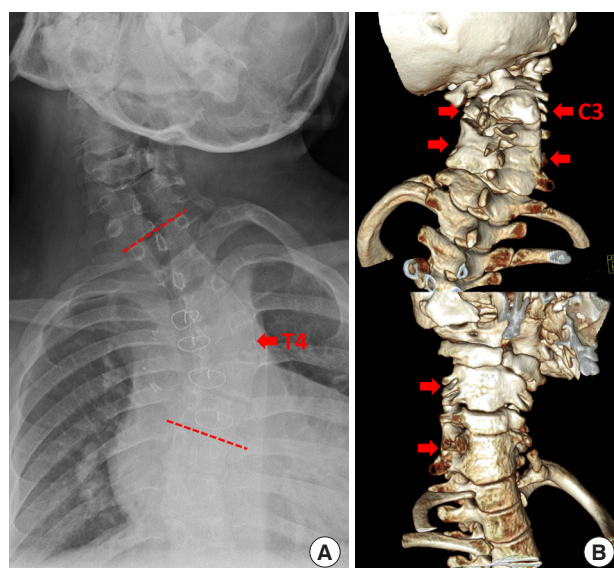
(A) Plain radiography reveals left thoracic scoliosis at T4 with 50 degrees of Cobb's angle. (B) Three-dimensional computed tomography representing C3 hemivertebrae and multisegmental fusion, C4 to C6, of the cervical spine (indicated by arrows).
